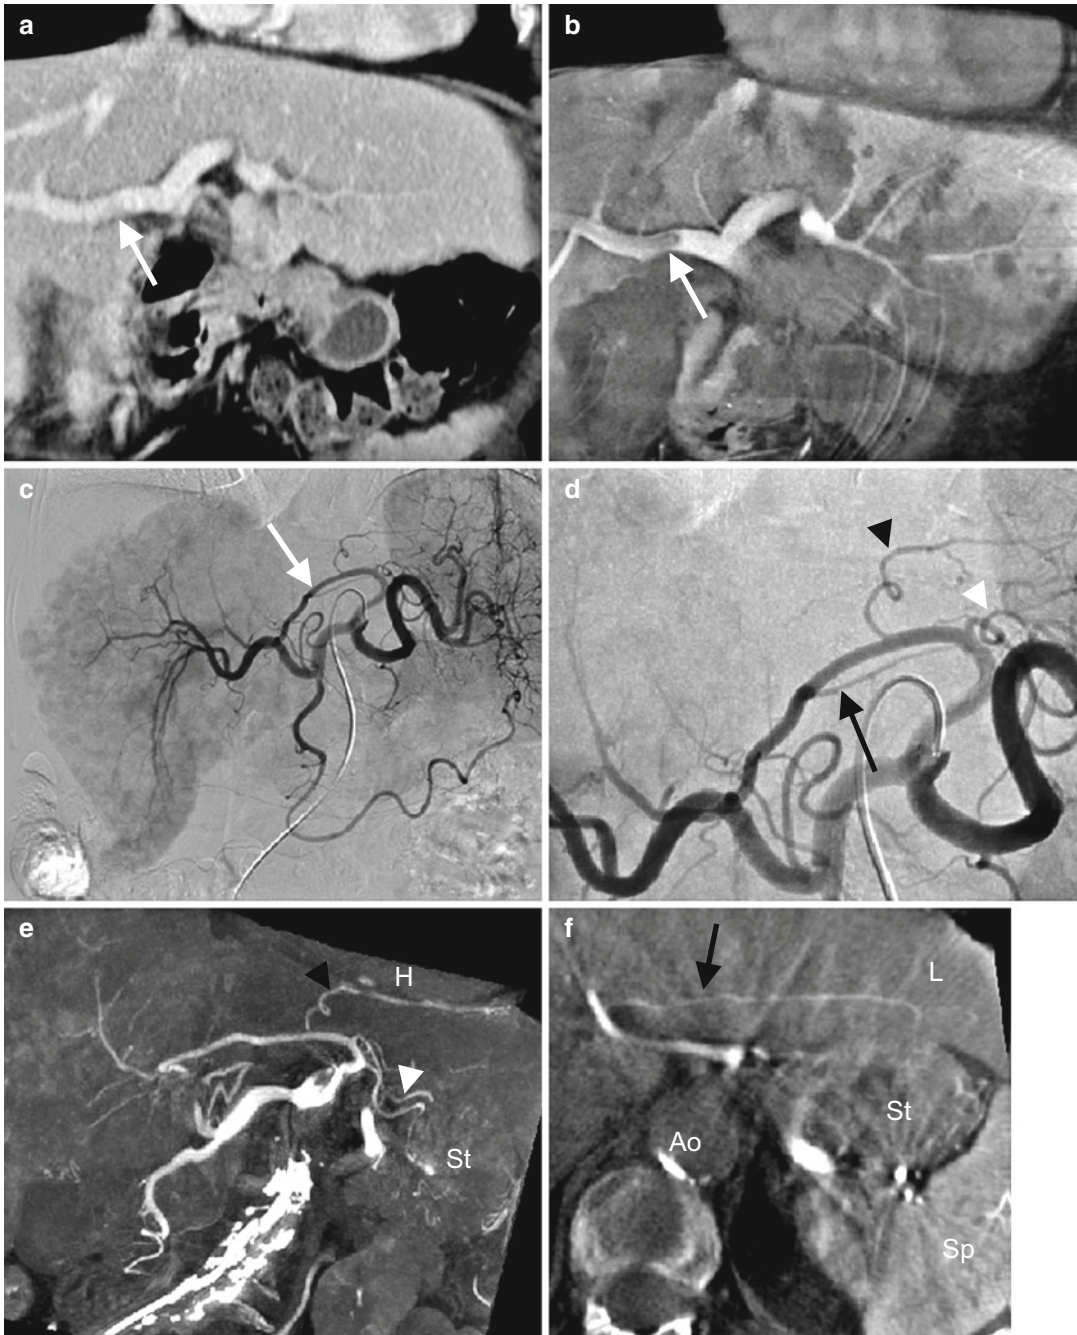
(a–f) TACE of the liver (a, b). Coronal MPR (3 mm) of the MSCT (a) and the C-arm CT (b), both in the portal venous phase. The disseminated hepatic metastasis as well as the segmental partial thrombosis of the portal vein (arrow) can be better appreciated with C-arm CT. (c) DSA shows the left hepatic artery feeding liver segments 2, 3, and 4 (arrow) coming off the prominent left gastric artery. (d) Enlarged view of the DSA shown in (c). Clear classification of the three proximal side branches of the left gastric artery could not be achieved on
